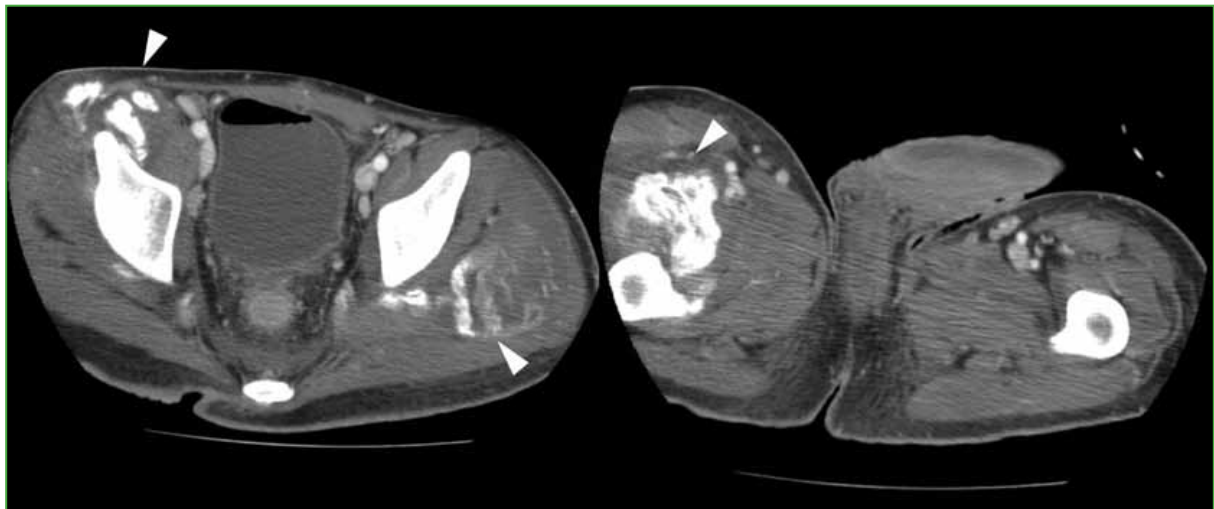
Computed tomography of the pelvis. Mature calcifications in relation to the right iliopsoas muscle and small peripheral calcifications in the left gluteal region.
